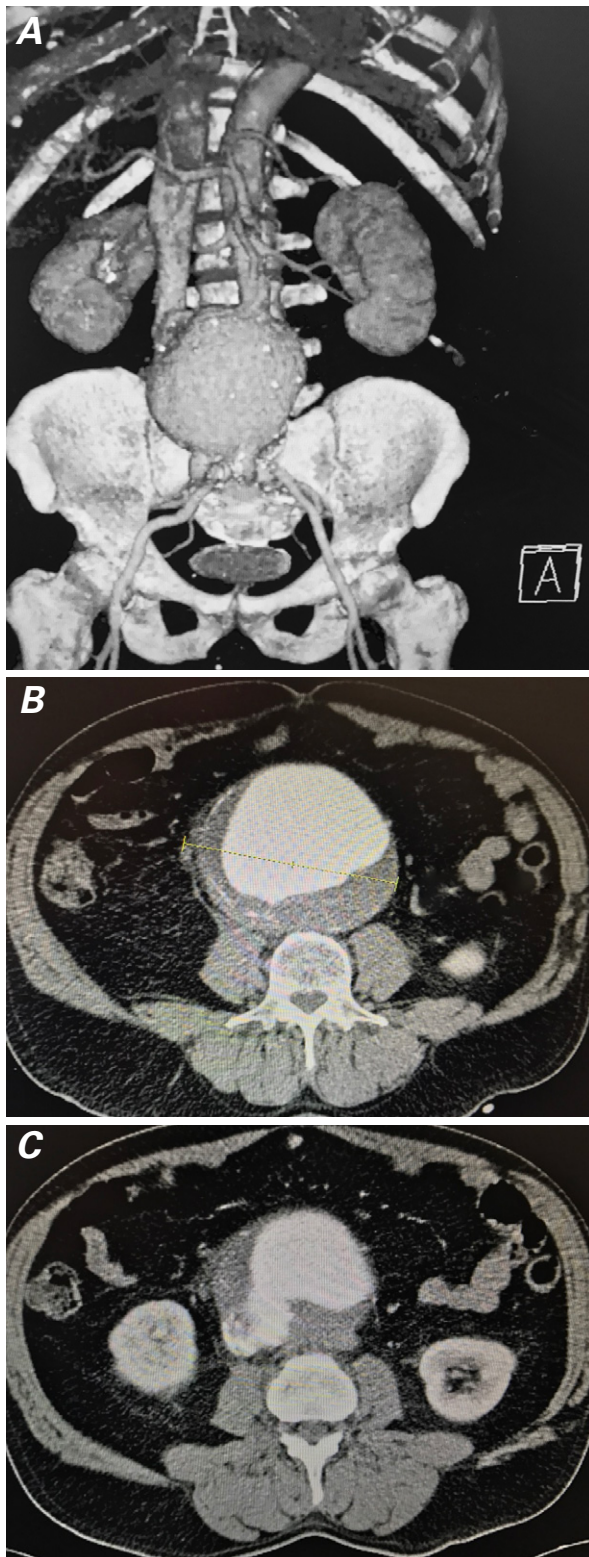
Preoperative abdominal computed tomographic angiograms. A) The coronal view (3-dimensional reconstruction) shows a 13-cm abdominal aortic aneurysm with communication and synchronous filling of contrast medium between the aorta and inferior vena cava. Transverse views show B) the aneurysm and no evidence of retroperitoneal rupture, and C) the aortocaval fistula.
